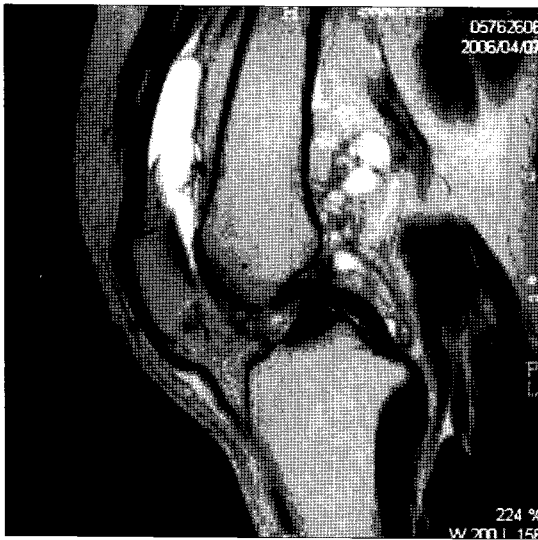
Initial MR image, Knee MRI shows thickened joint capsule, joint effusion and nodular synovial hypertrophy.
